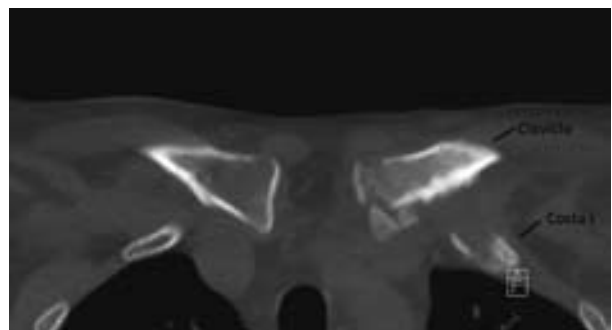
Postoperative transverse CT image showing an adequate costoclavicular space.
